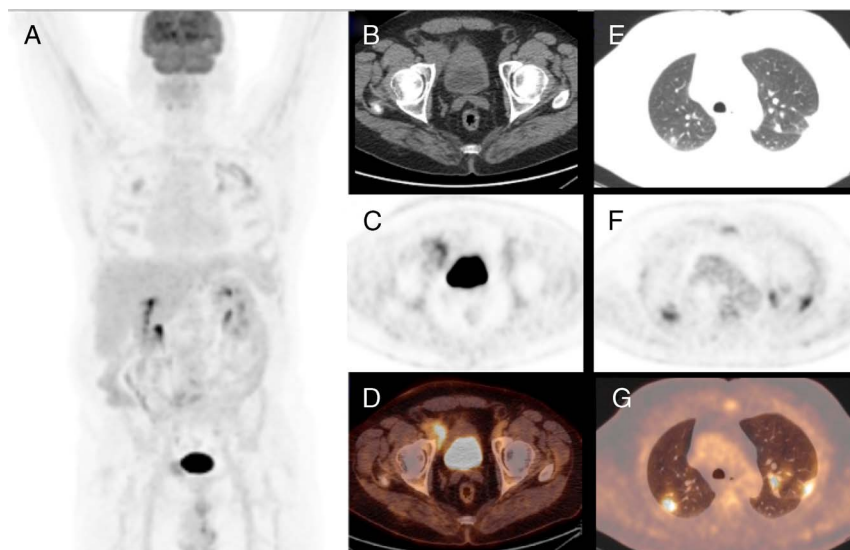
A 62-year-old man affected by follicular lymphoma underwent PET/CT scan for evaluating treatment response after 6 cycles of chemotherapy, and PET/CT showed a partial metabolic response with persistence of increased FDG uptake to an inguinal node (A–D) and the appearance of several bilateral lung consolidative and FDG-avid nodular areas, especially in the superior lobes with SUV_{max} of 9 (E–G). Being the pattern atypical for COVID-19, the patient started new chemotherapy regimen, but after the early onset of cough and dyspnea, RT-PCR test was done with positive finding for COVID-19. Chest radiographs and CT is the preferred examinations for screening, diagnosis, and monitoring of COVID-19 pneumonia.^{1–3} In this setting, the role of ¹⁸F-FDG PET/CT is still unclear with only few cases present.^{4–10} ¹⁸F-FDG PET/CT is a noninvasive tool with a significant role in evaluating several phlogistic and infectious pulmonary diseases, such as sarcoidosis and tuberculosis.¹¹ However, usually lesions presenting as GGOs are unlikely to have FDG uptake.¹² In agreement with previous articles,^{6–8} our patients were characterized by the presence of bilateral peripheral consolidative areas and/or GGOs. All had increased FDG uptake higher than blood pool activity. COVID-19 do not seem to be associated with lymph node involvement; however, Qin et al⁶ reported an increased nodal FDG uptake in 3 of 4 cases. Of course ¹⁸F-FDG PET/CT is not routinely recommended for pulmonary lung inflammatory diseases and not indicated in an emergency setting, but our findings underline that COVID-19 pneumonia are characterized by high ¹⁸F-FDG uptake in most cases despite GGOs appearance.
